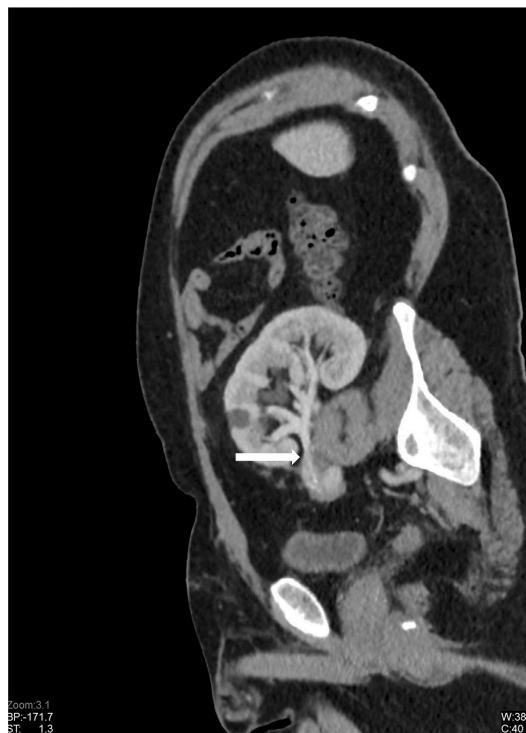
Multiplanar oblique reconstruction of the CT renal angiography confirmed a tight focal stenosis approximately 2.5 cm distal to the anastomosis of the transplant artery to the right external iliac artery (arrow).
